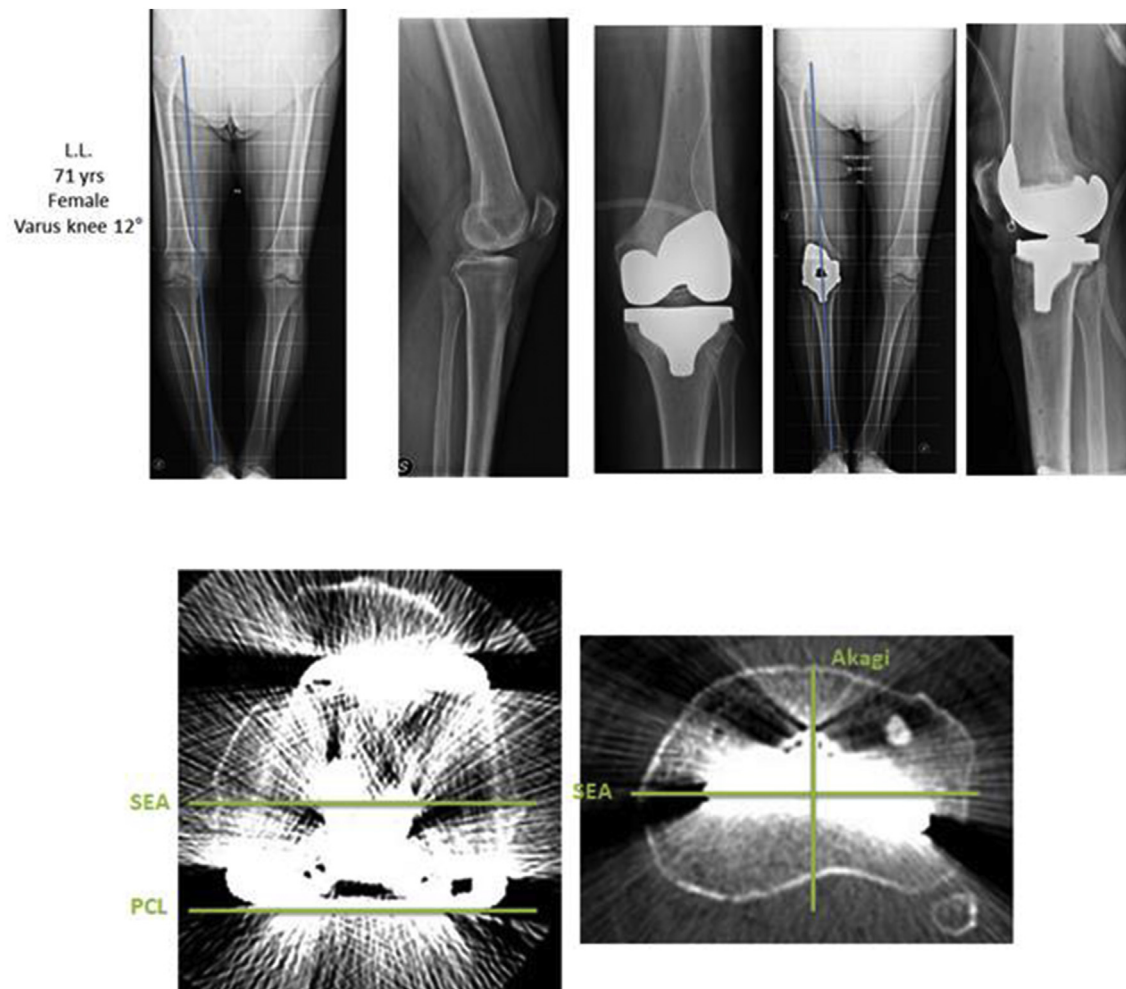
A: Radiographs of a female patient before and immediately after surgery, B: CT scan of the same patient 5 days after surgery.
